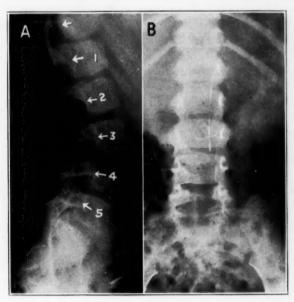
(case 2).—Roentgenograms of the lumbar portion of the spine of a patient with a teratoma. A, lateral view; B, anteroposterior view.
